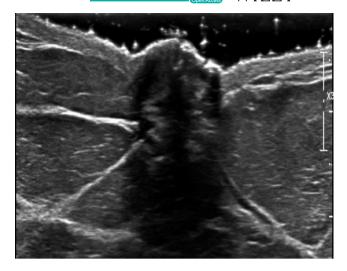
Ultrasound with suspicious calcifications within flattened left nipple.
